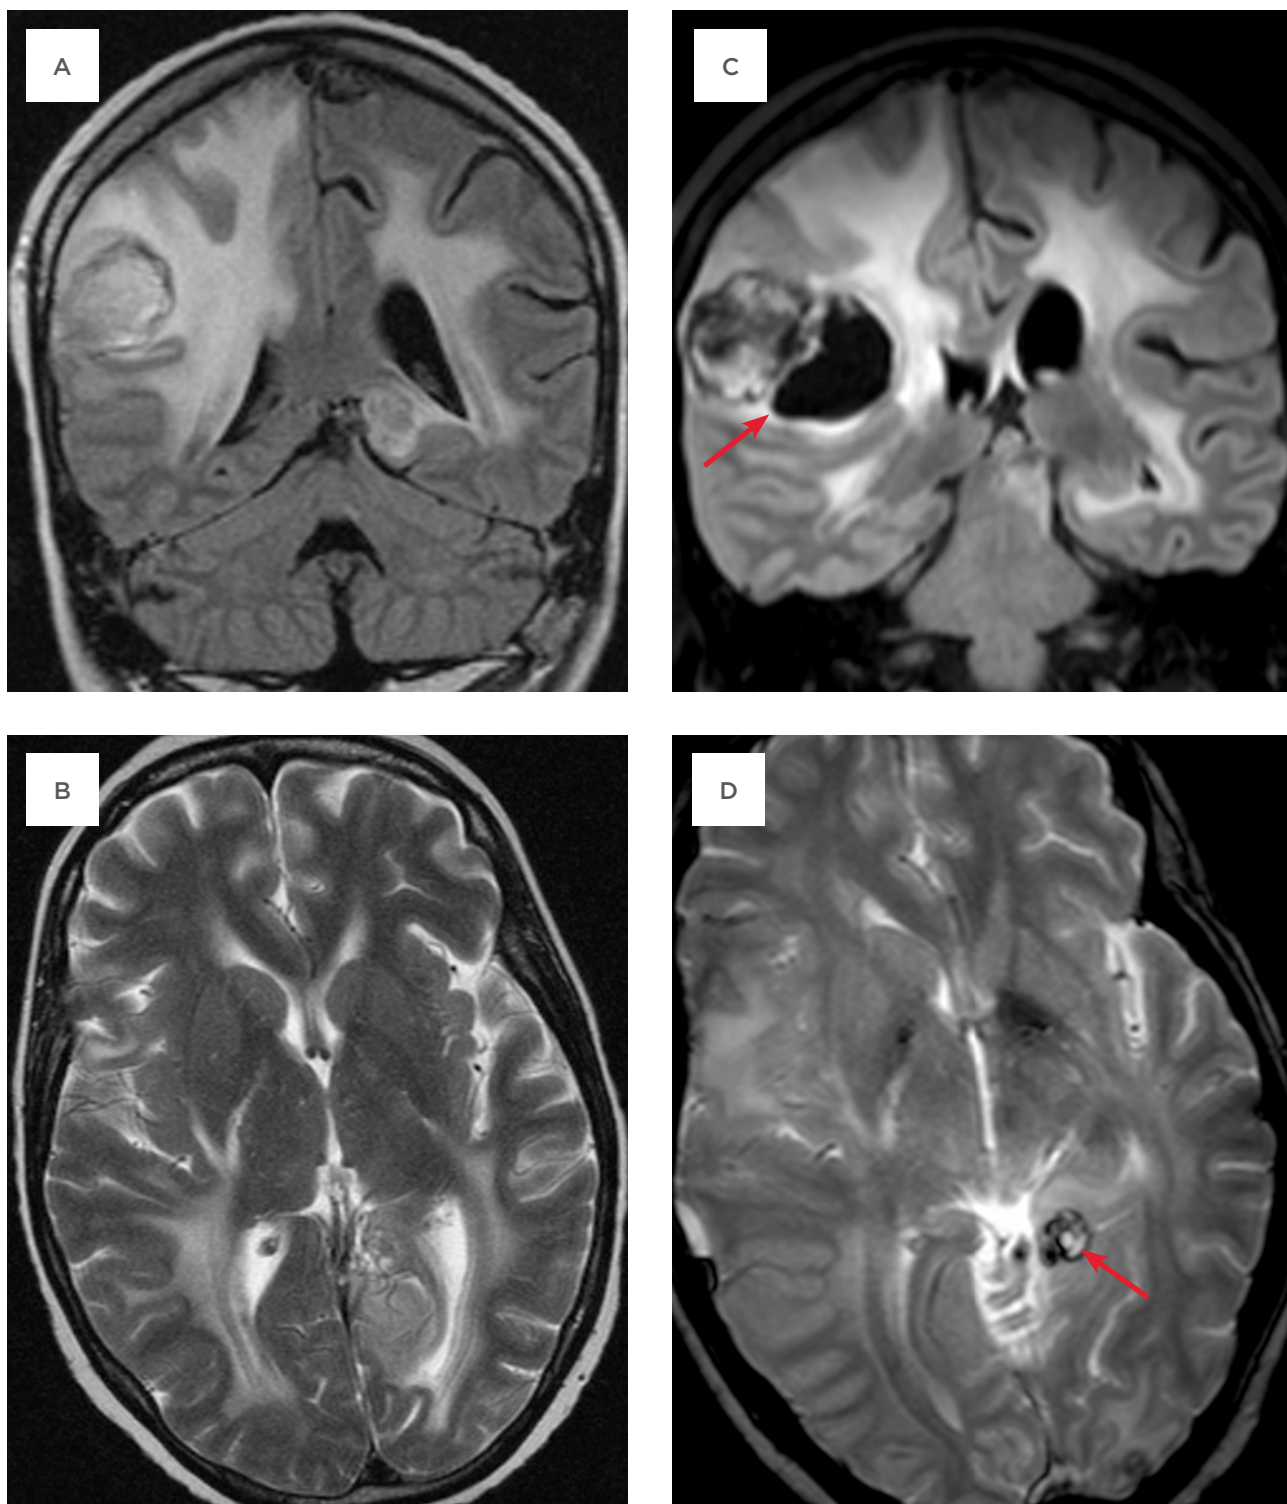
MRI scans showing brain metastases before and during treatment.
